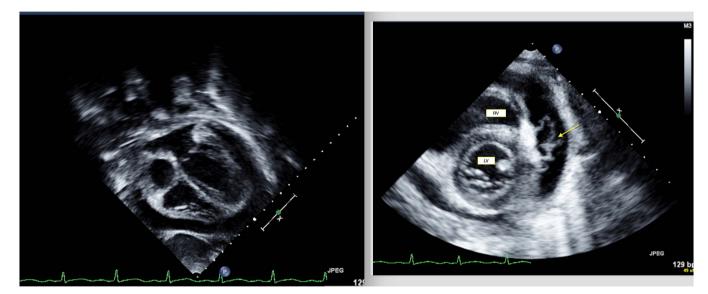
Echocardiographic images before pericardial window drainage. Description: *Left* – Four-chamber view showing moderate, circumferential effusion. *Right* – Subcostal view showing the presence of thick fibrin stranding (*arrow*). LV = left ventricle; RV = right ventricle.
